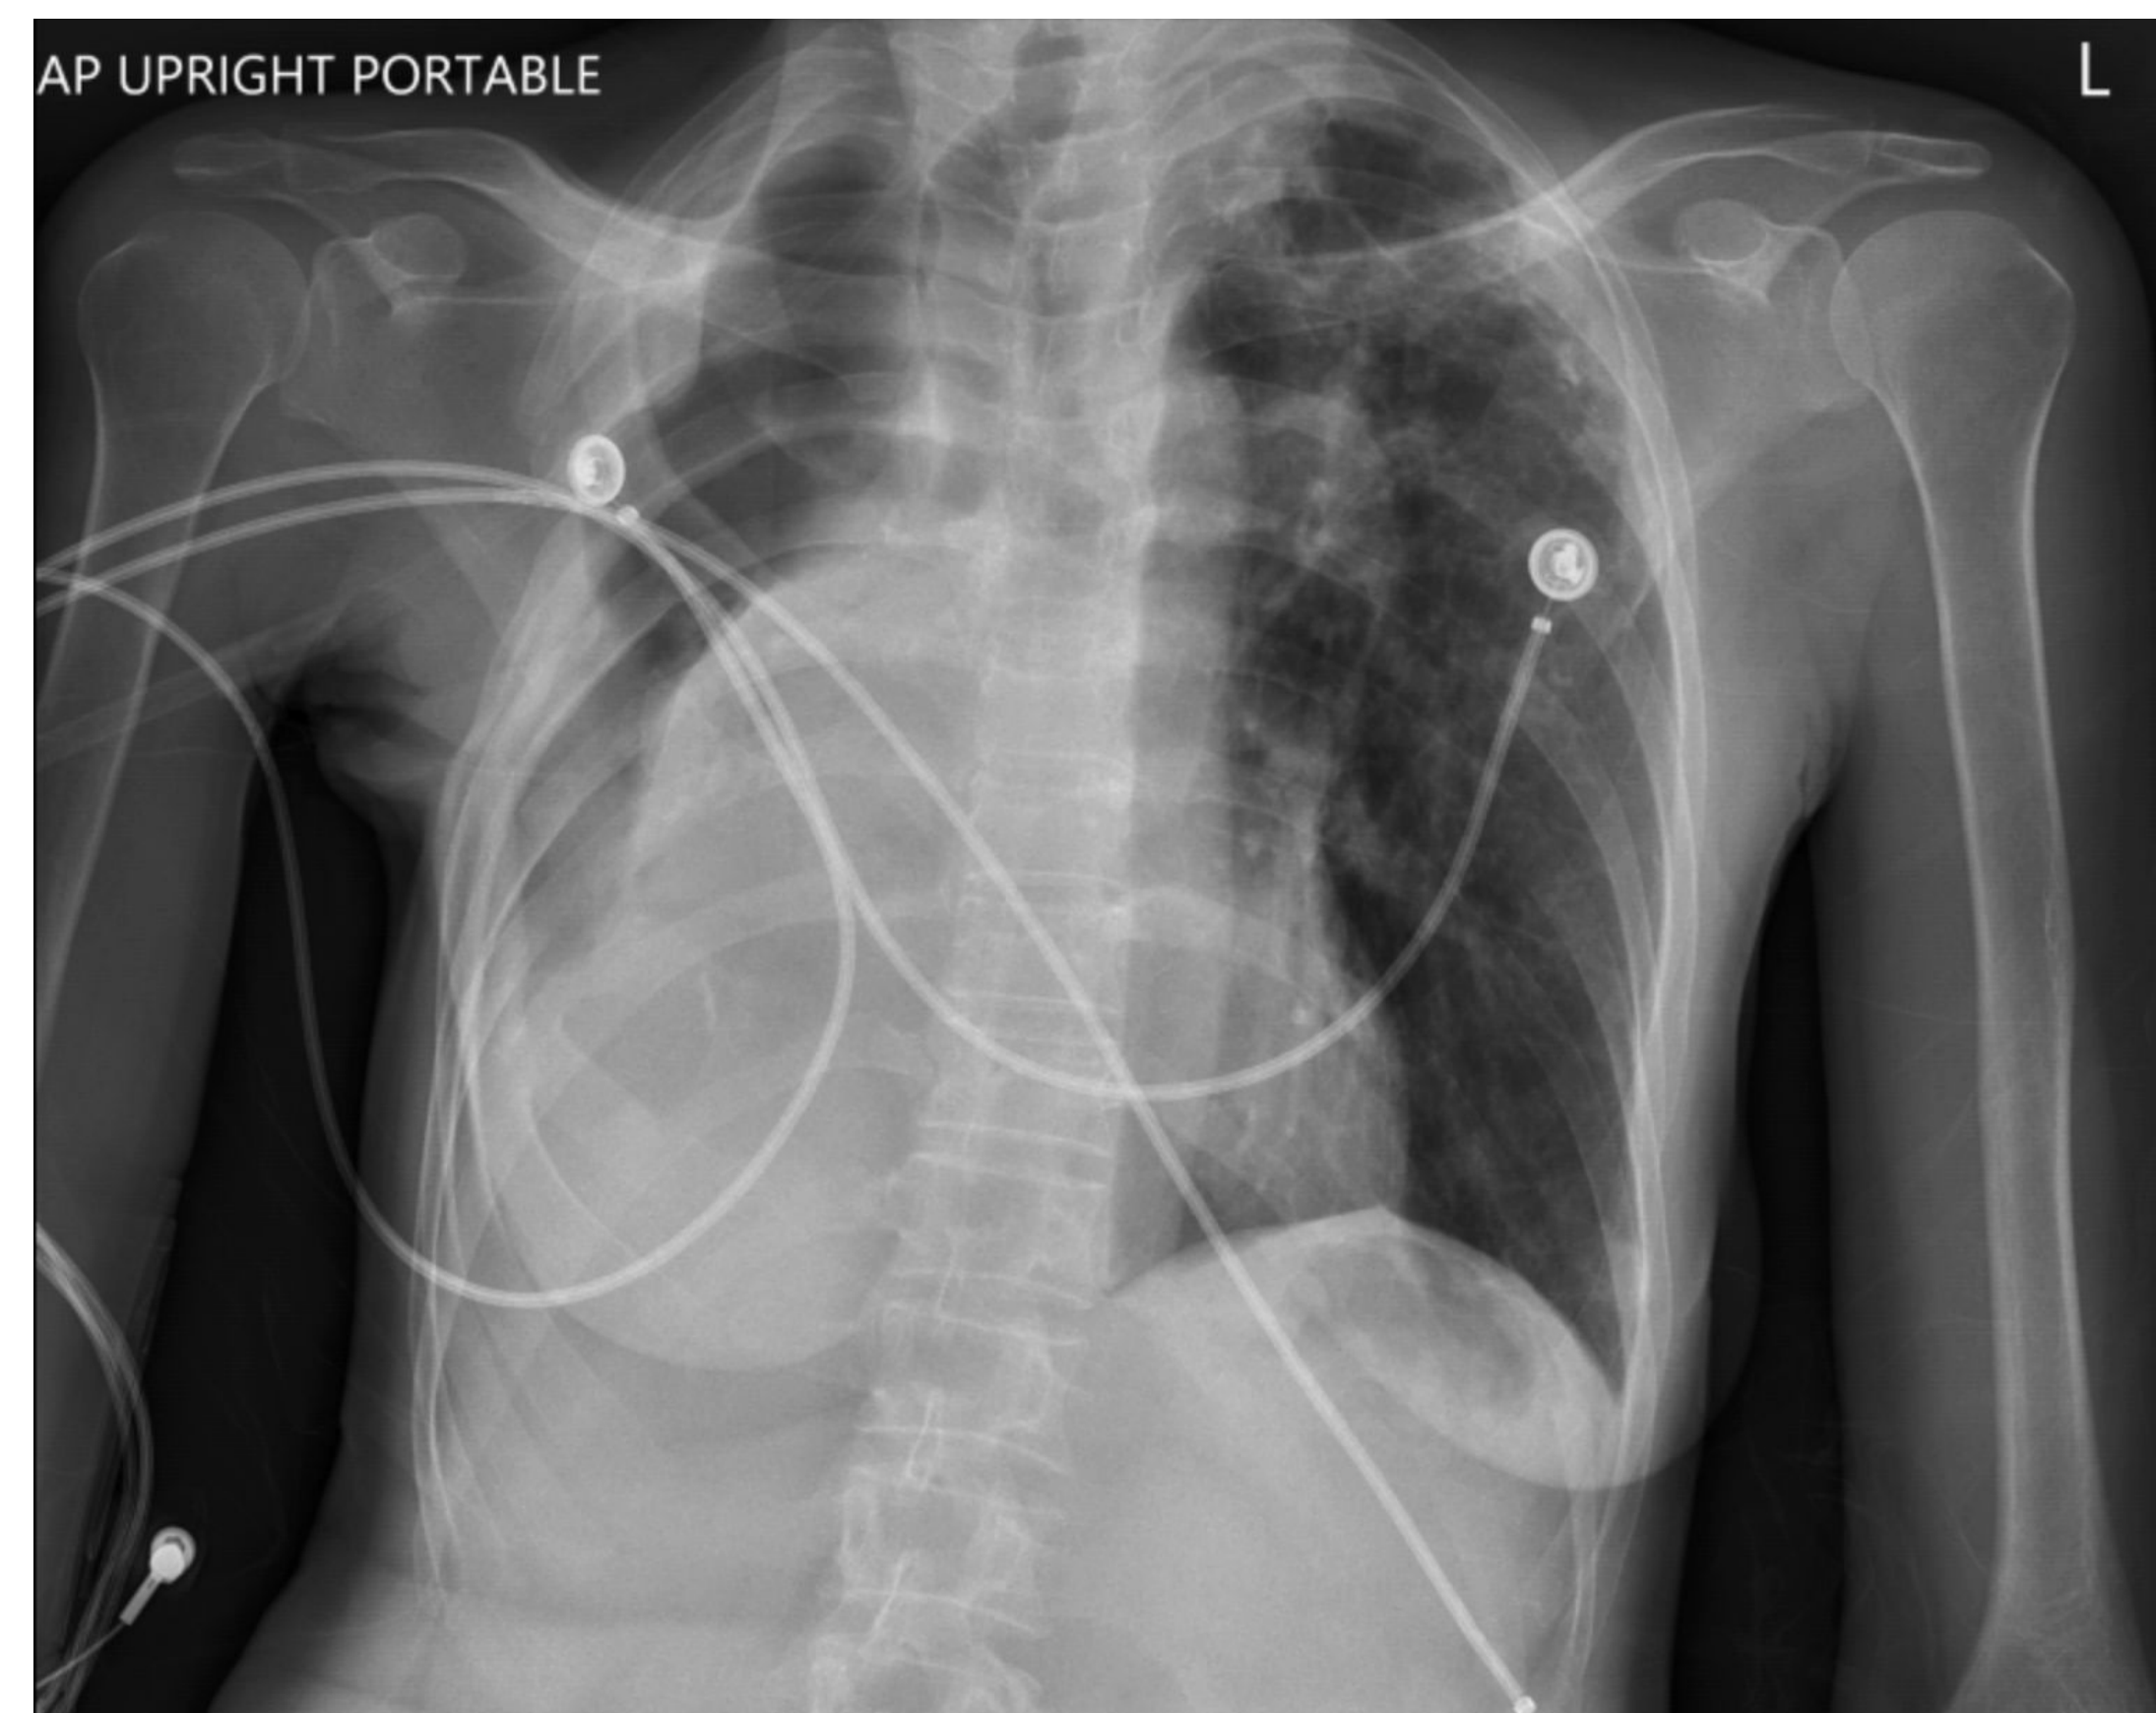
Chest X-Ray. There is a small right lung volume with large cavitory lesion in the right upper lung field. There are right lower lobe infiltrates/consolidations, and a small right pleural effusion.
